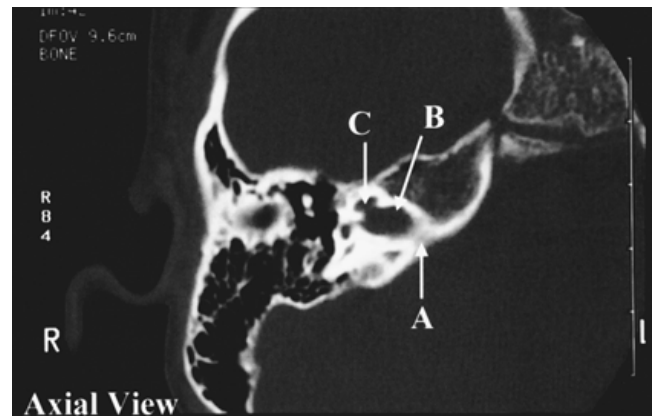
A high-resolution computed tomographic scan of a patient's inner ear at the modiolar level showing dilation of the internal auditory canal (IAC, labeled B), hypoplasia of the basal turn of the cochlea with no detectable bony modiolus (C) providing a route of direct communication between the subarachnoid space of the posterior cranial fossa (A) and the perilymphatic space of the inner ear. Stapes fenestration surgery is contraindicated in this patient due to the high risk of hearing loss from a cerebrospinal fluid "gusher."
